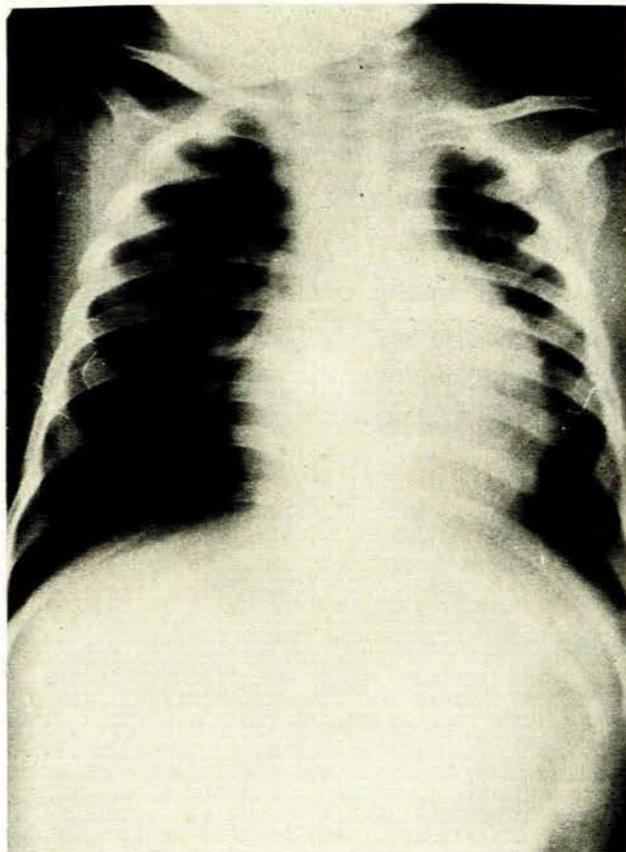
X-ray taken 20 days after admission showing reduction in size of cardiac shadow.
